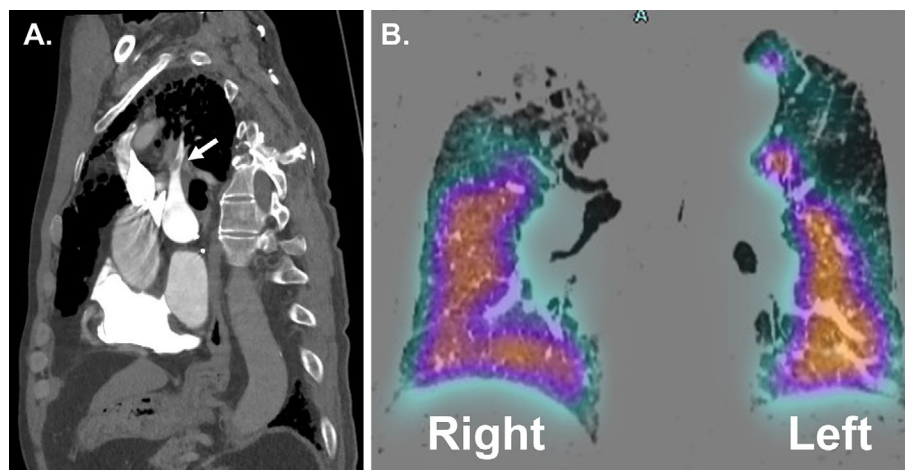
(A) Re-constructed chest contrast enhanced CT shows abrupt narrowing of the right A₁ pulmonary artery (arrow). (B) Lung perfusion scintigraphy was performed. The orange area indicates abundant pulmonary blood flow, while the light blue area signifies poor pulmonary blood flow. Unhighlighted areas indicate interruption of pulmonary blood flow. In this patient, the pulmonary blood flow was notably reduced, particularly at the apex of the right lung and at the upper and lateral areas of the left lung. CT: computed tomography
